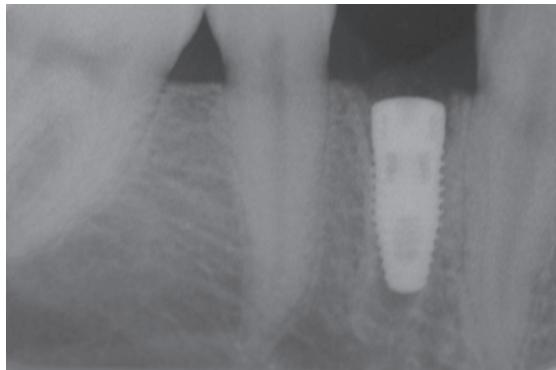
Post-operative radiograph of dental implant placement.
